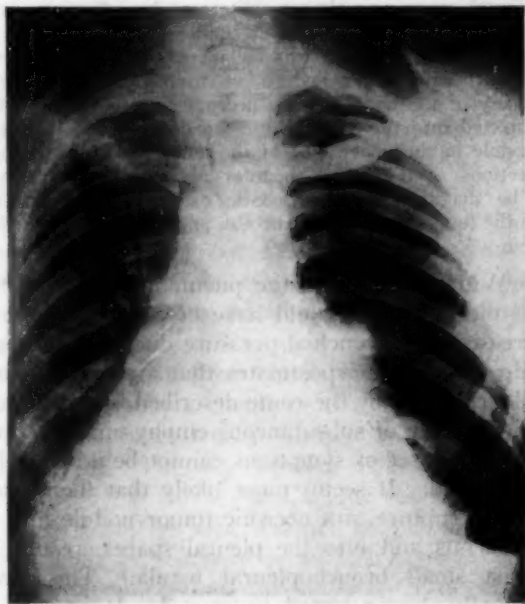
(case 1).—Roentgenogram taken Dec. 31, 1943. The right lung is completely collapsed, and irregular rounded tumor nodules project from the collapsed area. The left lung shows multiple small metastatic foci, particularly in the base.
